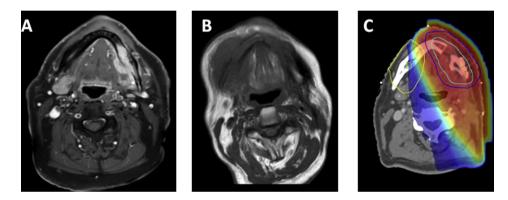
Example of type E recurrence at the primary site (extraneous, primary). Patient with pT4apN0MO squamous cell carcinoma of the left mandible. Treatment was with hemimandibulectomy, fibula reconstruction and ipsilateral neck dissection followed by adjuvant radiotherapy 66 Gy in 33 fractions. (A) Preoperative magnetic resonance imaging (MRI; fat saturated T1 with gadolinium) showing tumour on the left hemimandible. (B) MRI (T1W) showing recurrence around the native right hemimandible (extended to the junction with the graft) 8 months after radiotherapy. (C) Planning computed tomography scan with the site of recurrence shown (yellow) following contouring on deformably coregistered recurrence MRI with centroid (green) of recurrence volume, with a colourwash of the plan dosimetry. The centroid and most of the recurrence volume lie beyond the high-dose volume.
